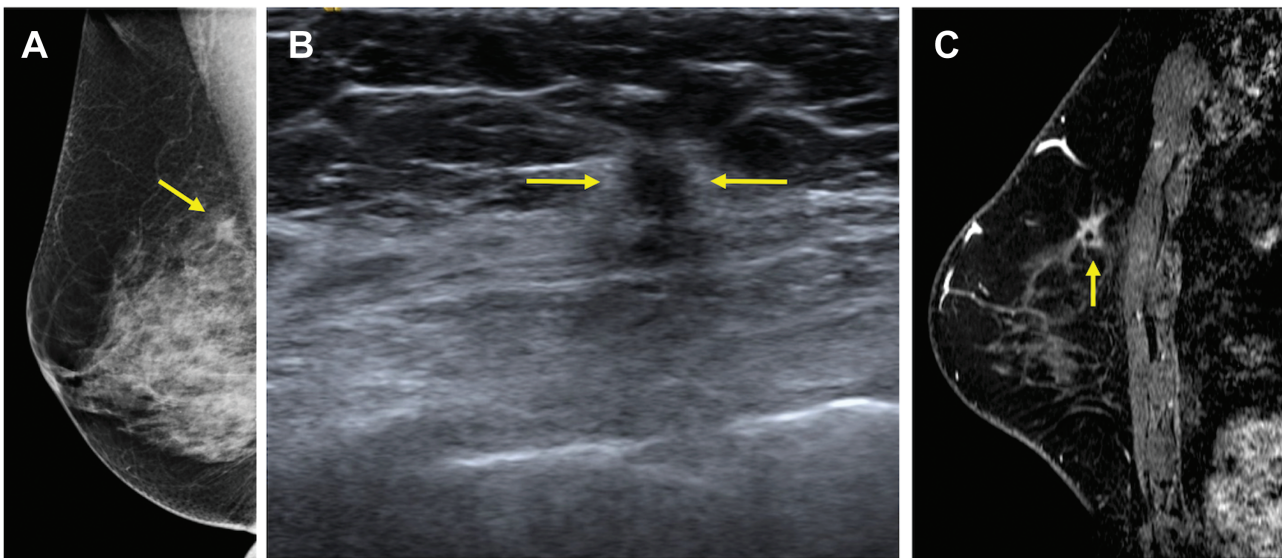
70-year-old woman who presented with a screening-detected mass in the right breast in the upper inner quadrant shown to be an invasive lobular carcinoma (ILC) (Nottingham grade II, estrogen and progesterone receptor positive, HER2 negative) with associated lobular carcinoma in situ on core-needle biopsy, which serves as an example of concordant depiction of the span of ILC on both conventional imaging and MRI when compared to final pathology. A: Diagnostic mediolateral oblique mammogram demonstrated an irregular mass with spiculated margins measuring 12 mm (arrow). B: Targeted US depicted a round mass with indistinct margins measuring 8 mm (arrows). C: MRI performed after core-needle biopsy and prior to surgery depicted the finding as an irregular mass with spiculated margins measuring 12 mm and containing a biopsy marker clip (arrow). Final pathologic size was 12 mm on mastectomy, which was concordant with maximal size on conventional imaging and MRI.
